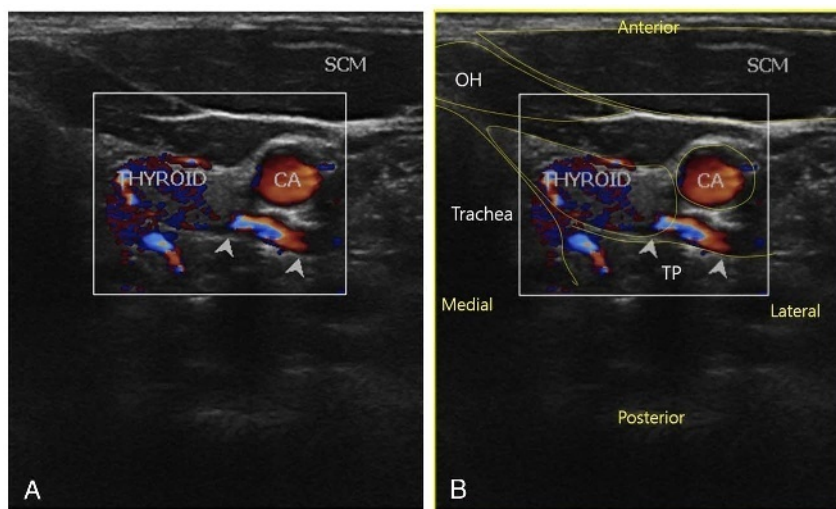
Transverse sonographic image with color Doppler showing the inferior thyrovascular space. CA indicates carotid artery; SCM, sternocleidomastoid.
